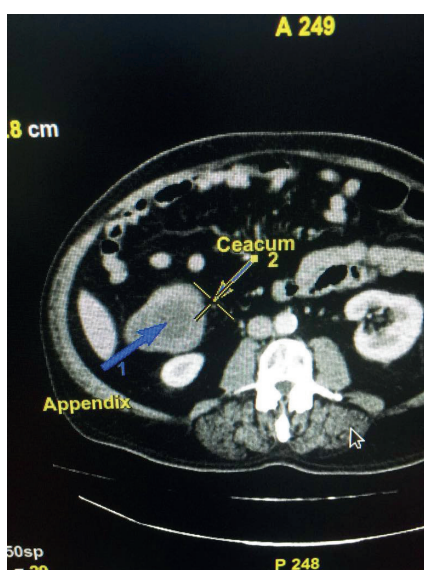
Appendiceal mucocele leading to intussusception in a computed tomography
